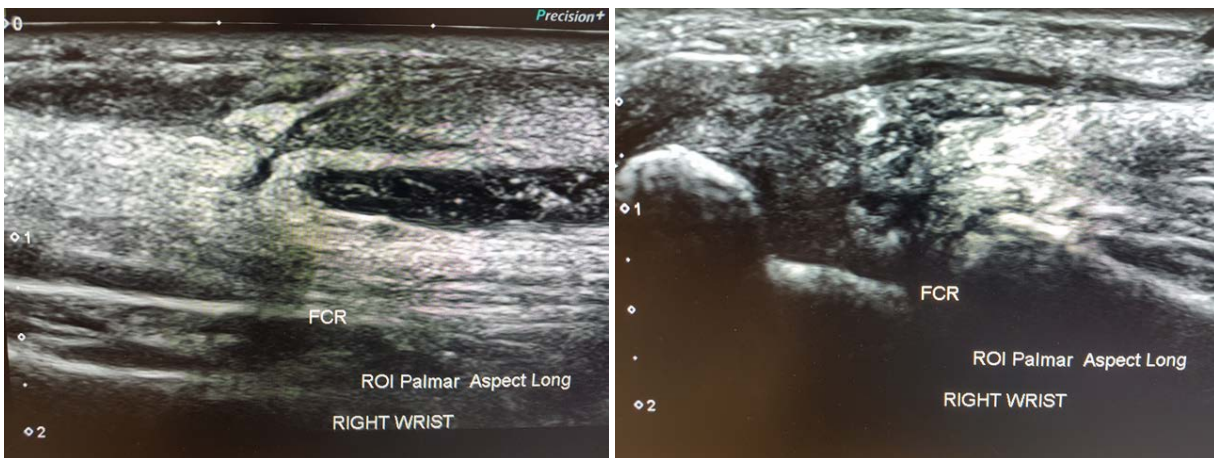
dynamic ultrasound examination of the right polar wrist demonstrating a complete full thickness tear of the FCR tendon at the myotendinous junction with retraction. The other flexor and extensor tendons appear within normal limits.
